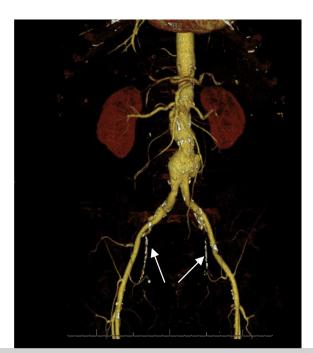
Preoperative computed tomography (CT) scan with three-dimensional reconstruction demonstrates 5.2-cm \times 4.3-cm bilobed fusiform aneurysm along with calcified bilateral internal iliac arteries (IIAs; *arrows*).
